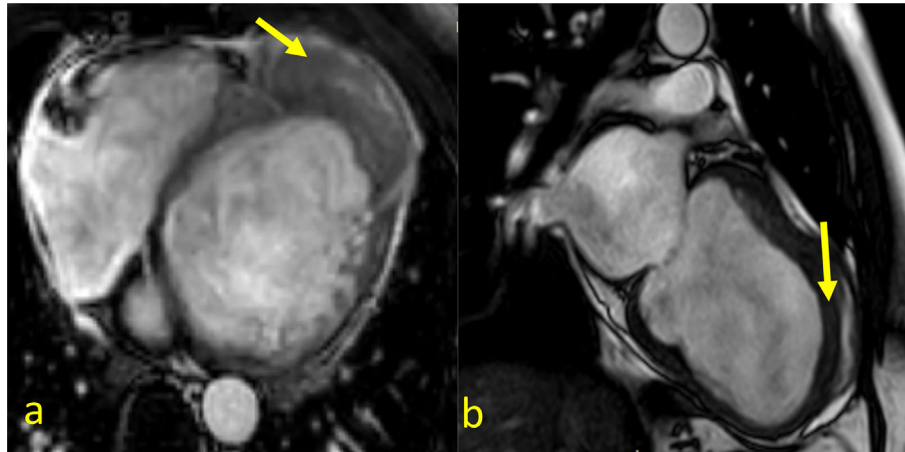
Control MRI after 20 days: SSFP (steady-state free-precession) Cine Sequence: Axial 4 cavities (a), (b) long axis of the LV: Partial regression of dissecting intra myocardial hematoma (yellow arrows).
